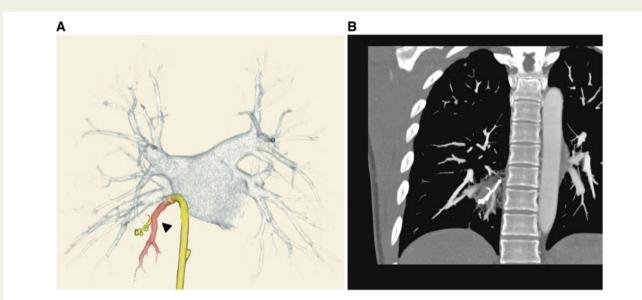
(A) Preoperative three-dimensional constructed enhanced computed tomography shows the catheter tip which perforated the posterior basal vein (red colour) of the right inferior pulmonary vein (triangle). The circular mapping catheter and transseptal catheters are shown in yellow. (B) Preoperative transverse computed tomography (frontal plane) shows the circular mapping catheter and intrapulmonary haemorrhage caused by perforation of the right inferior pulmonary vein (V10: posterior basal vein).
